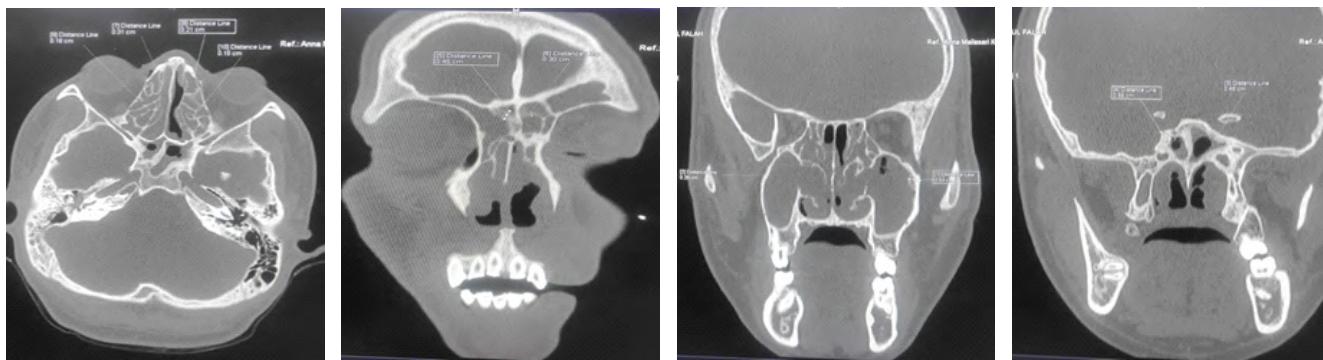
Measurement of the rhinosinusitis severity, Lund Mackay CT score (LMS) = 22, Global Osteitis Score (GOS) = 38 and Kennedy Osteitis score = 8
